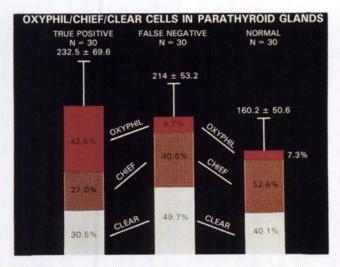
Overall cell numbers versus parathyroid scintigraphy.
